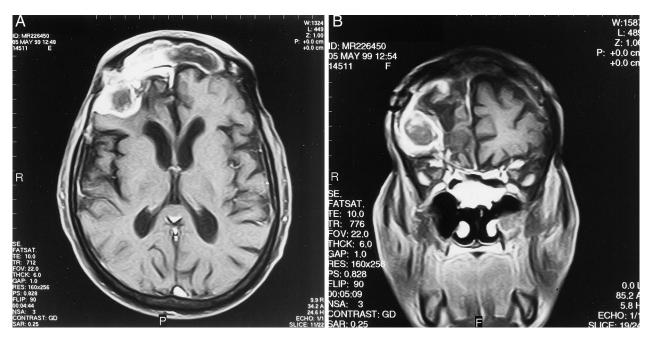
T1-weighted contrast enhanced magnetic resonance imaging axial and coronal images show approximately a 4×4 -cm ring enhancing mass in the right frontal lobe.
